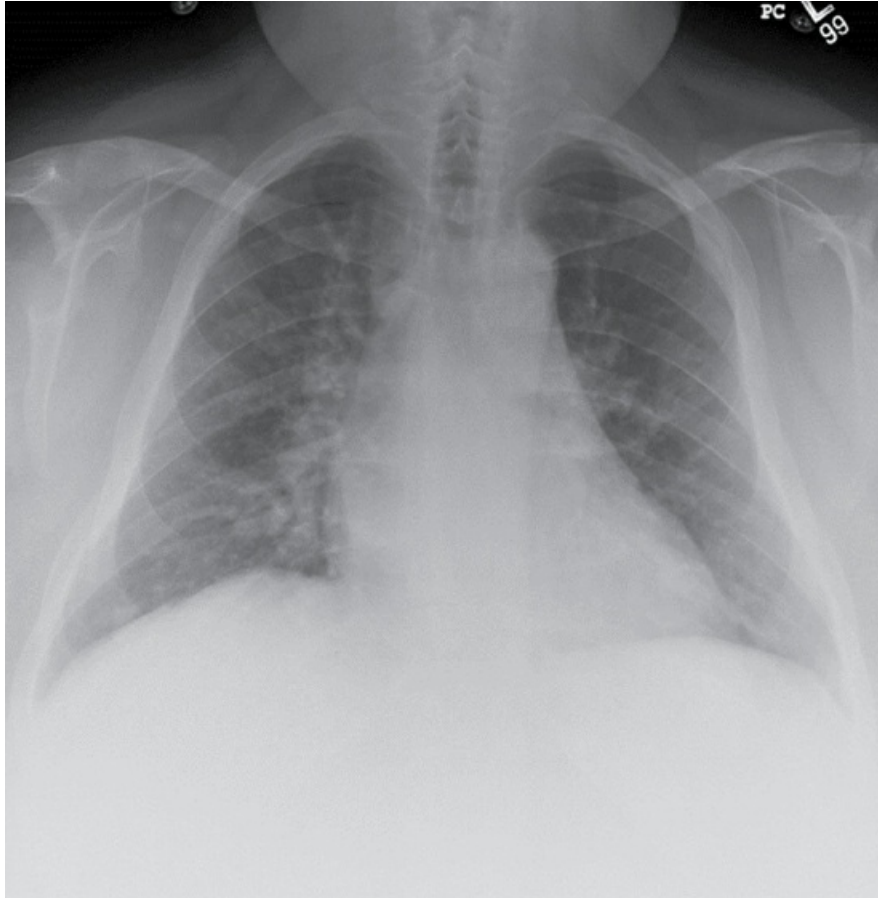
Posteroanterior chest radiograph showing diffuse but subtle bilateral interstitial infiltrates caused by influenza pneumonia. *Source:* (Courtesy of Dr. Laura Avery.)
